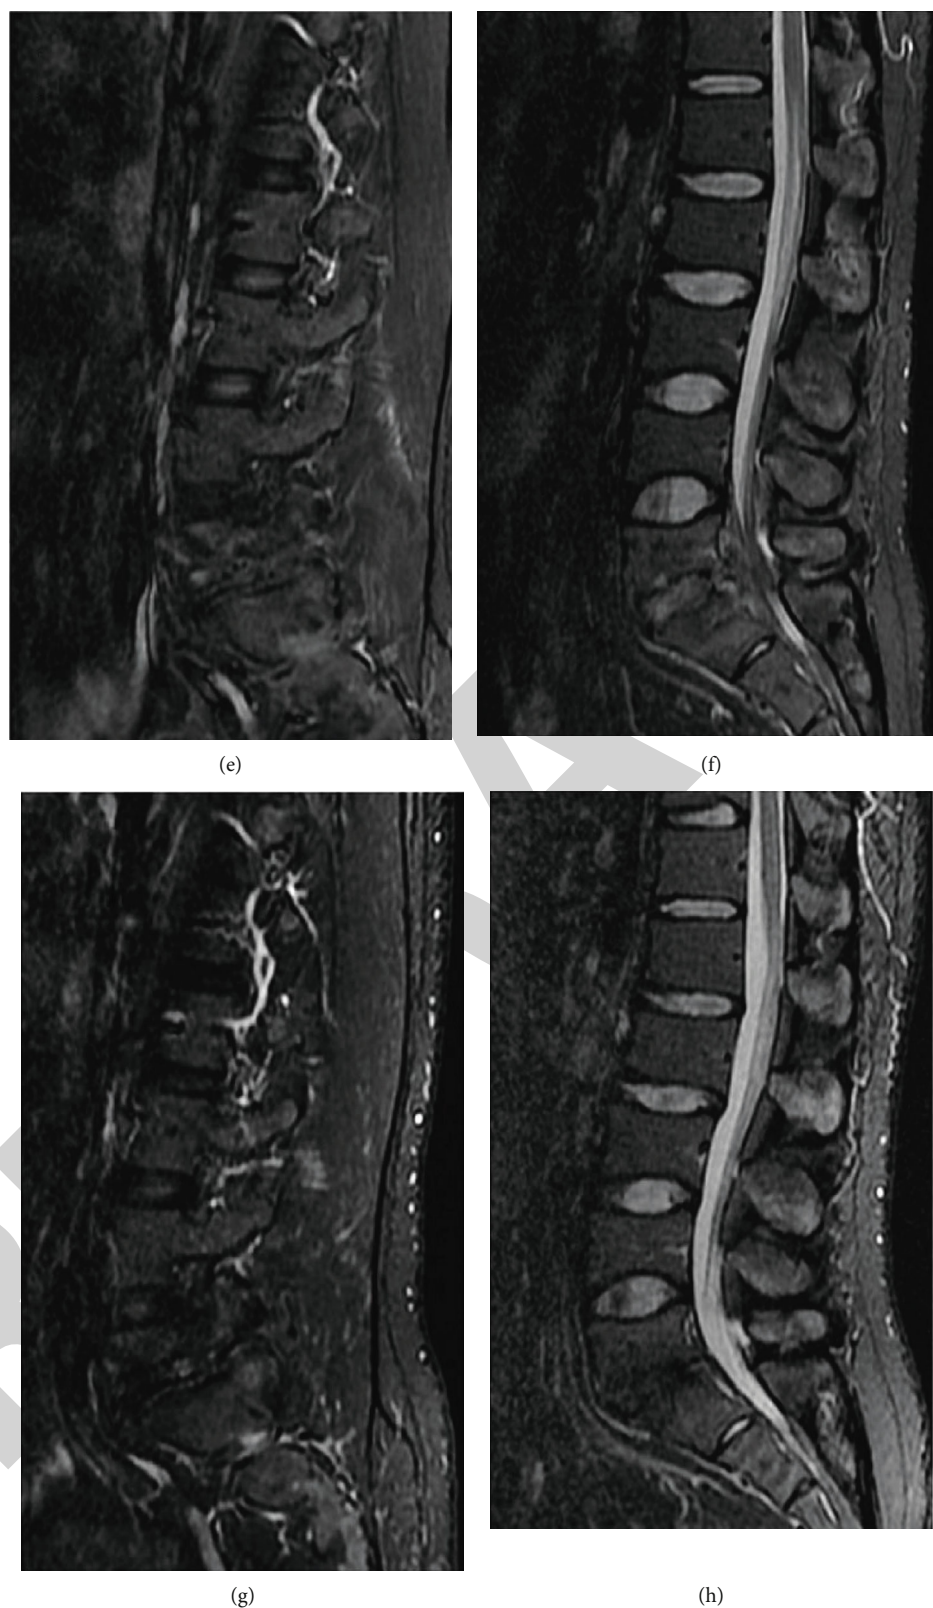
A 30-year-old man suffered from low back pain and right lower extremity numbness with lumbar spondylodiscitis. Preoperative MRI (a, b) and cross-sectional CT (c) showed psoas major abscess, epidural abscess, and vertebral bone destruction with nerve compression. Pola type C3. (d) The first-stage treatment with PELDID was performed, and lumbar tuberculosis was diagnosed by gene chip sequencing technology. (e, f) MRI of the lumbar spine after removal of the drainage tube 2 weeks after surgery showed that the abscess of the psoas major disappeared, and the abscess in the spinal canal improved significantly. Pola type B2 type. Antituberculosis drugs and braces were given. (g, h) MRI of the lumbar spine at the last follow-up showed that the psoas abscess and the intraspinal abscess disappeared.
